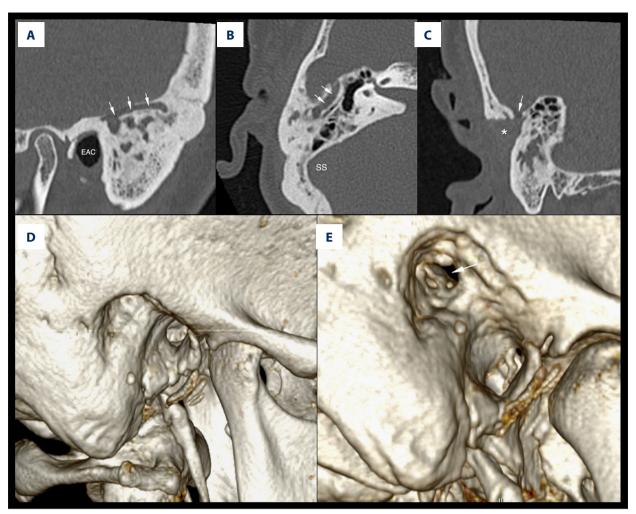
Multiplanar reformatting (A–C) and three-dimensional volume rendering (3D VR) (D) reconstructions of temporal bone computed tomography scan of a 53-year-old female with chronic otitis media after mastoidectomy (asterisk) of the right temporal bone. There was intraoperative profuse bleeding from a damaged petrosquamosal sinus (PSS; white arrows), which on referral was considered by the surgeon to have been caused by damage to the anteriorly located sigmoid sinus (SS). Normal location of the SS on axial scans (B) and postoperative changes of the mastoid (white asterisk) in the coronal plane (C) are shown. (A) Sagittal plane. (B) Axial plane. (C) Coronal plane. (D) 3D VR of the right mastoid; bony deficit after mastoidectomy is shown, with damage to the bony canal of the PSS.
